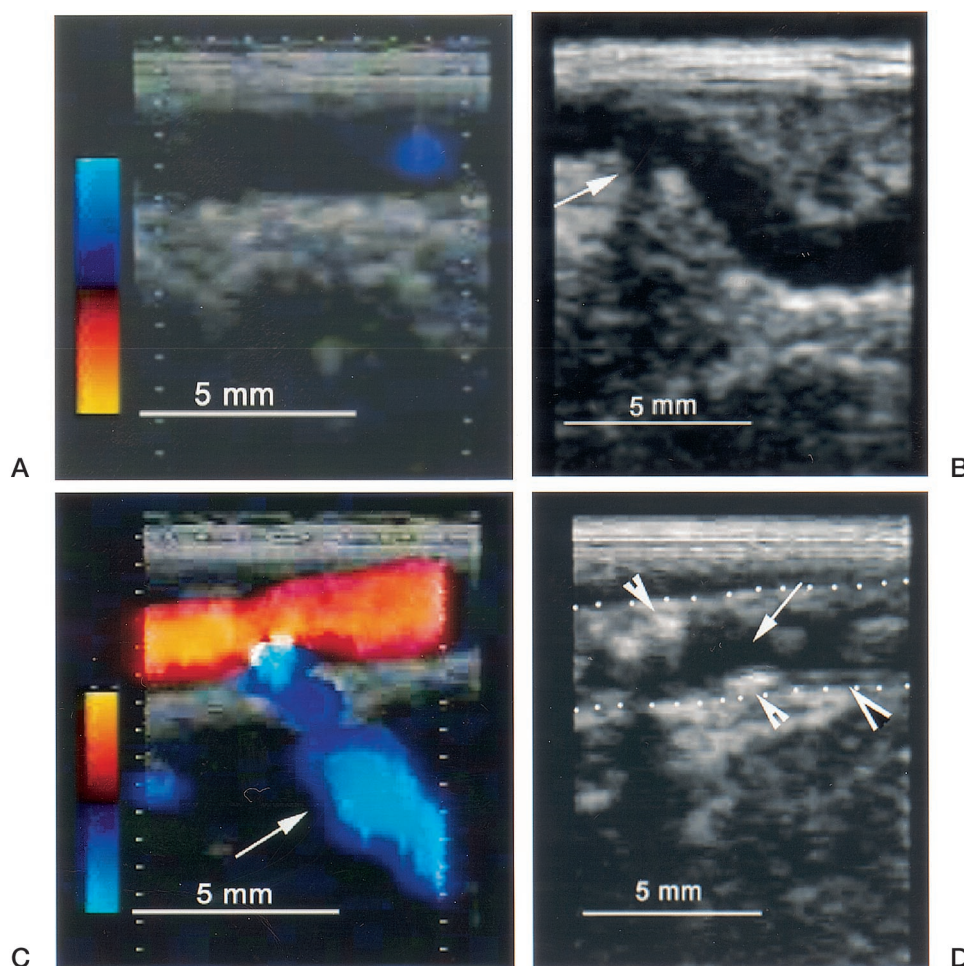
Images from a 10-MHz minitransducer. A, Optimal anastomotic site. No plaque and no perforating side branches were detected with color Doppler ultrasonography. B, Septal perforating side branch of LAD (arrow) was detected in B-mode, as well as partially intramural LAD course. C, Septal perforating side branch of LAD (arrow) was detected in color Doppler mode. D, Severely diseased segment of LAD (dotted lines) with atheromatous plaque and calcific deposits (closed arrowheads) and a part of the artery relatively free of plaque (open arrowhead) were detected. The arrow indicates the lumen.
